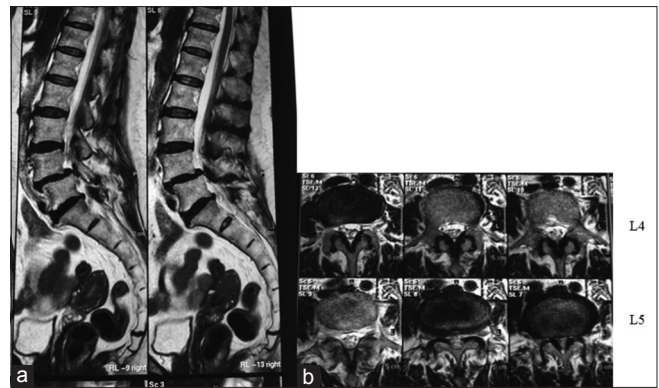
(a) Magnetic resonance imaging sagittal T2-weighted image lumbar-sacral showing L4/5 spondylolisthesis with disc prolapse. (b) Magnetic resonance imaging axial T2 lumbar showing disc protrusion with narrowing of right exit foramina and spinal canal stenosis
